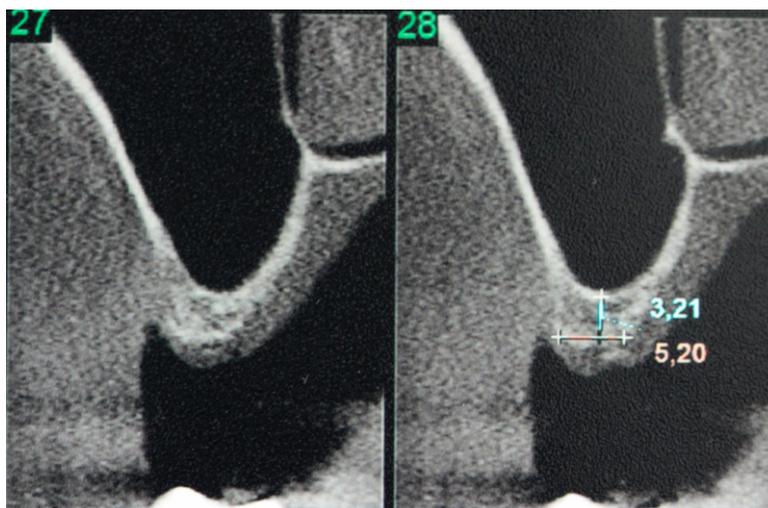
CT scan demonstrating the remaining bone height
